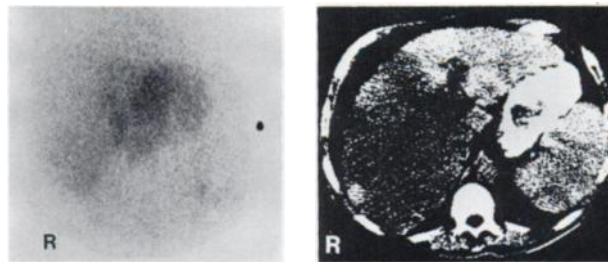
Anterior scintiscan of liver (left) with Tc-99m HIDA. Concentration of radioactivity is limited to left lobe. CT scan (right) showing decreased density in right lobe.
